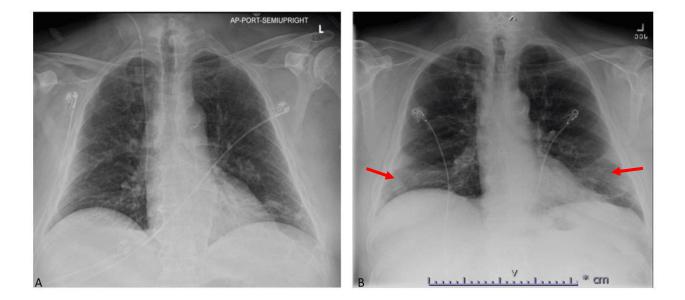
A) Portable anterior-posterior (AP) chest radiograph before starting daptomycin showing no focal opacities; B) Portable anterior-posterior (AP) chest radiograph upon admission showing patchy infiltrates and ground glass opacities in the lower lobes.
